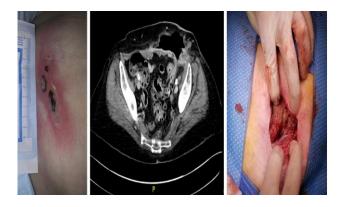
A 75-year-old female presented with abdominal wall abscess, erythema of the skin and an eschar (left). A bedside incision and drainage was done which appeared superficial. Subsequently, a CT pelvis demonstrated an abdominal wall necrotizing fasciitis secondary to a smoldering perforated diverticulitis (middle). Patient underwent mini laparotomy and washout, here the fascia is visible with underlying necrotic fatty tissue (right).
